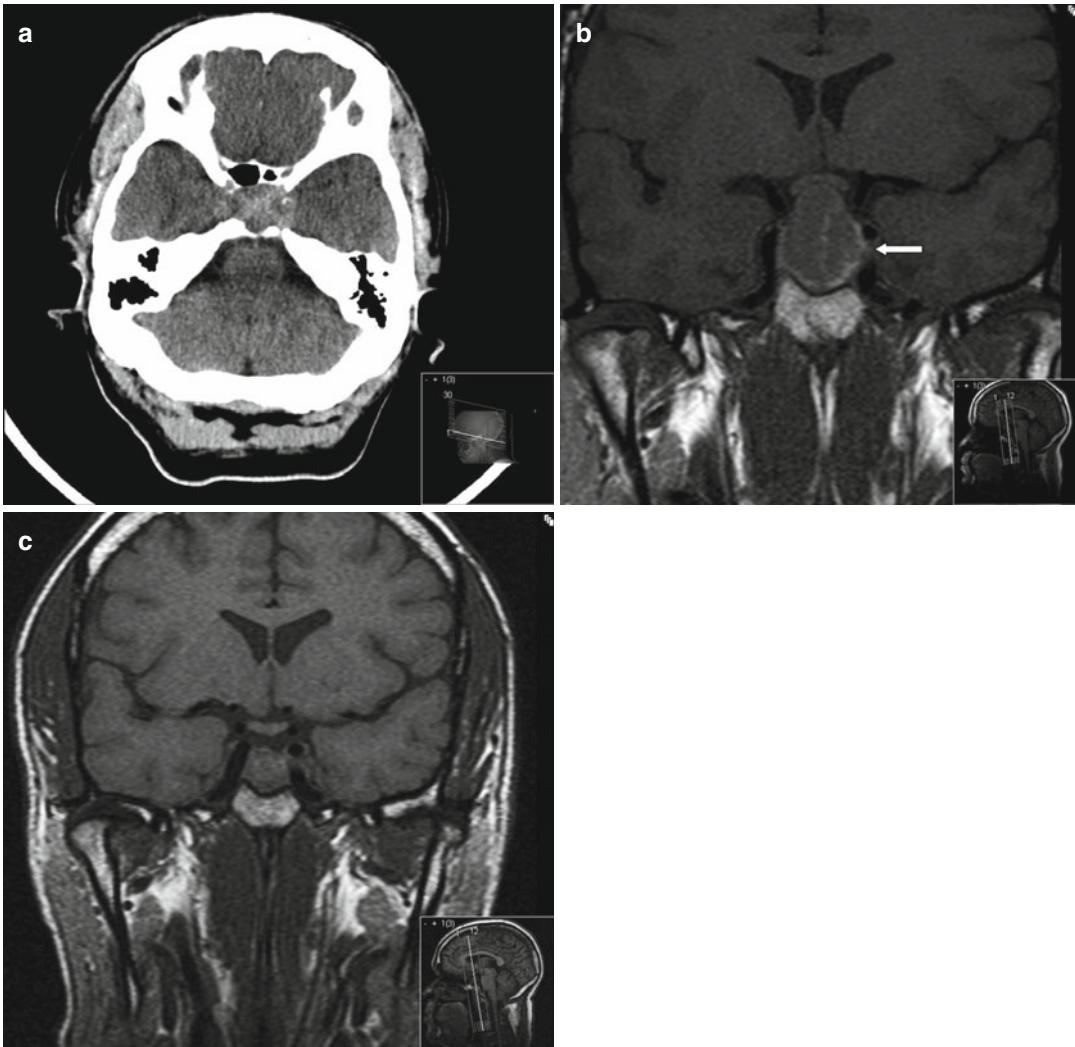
A 53-year-old man presented to our department with a 2-day history of headache, nausea, vomiting and blurred vision. (a) A haemorrhagic pituitary mass was shown on urgent CT scanning. (b) A pituitary macroadenoma with signs of recent haemorrhage was confirmed on
